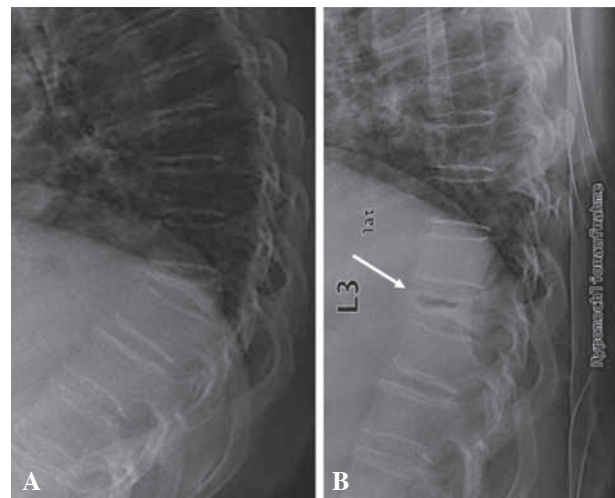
A) Conventional lateral X-ray of the thoracolumbar junction in erect position showing the collapsed Th10 vertebra. B) Lateral fulcrum radiograph revealing the non-union of Th10 with its pathognomonic intravertebral cleft (Kummel's sign) (white arrow).
